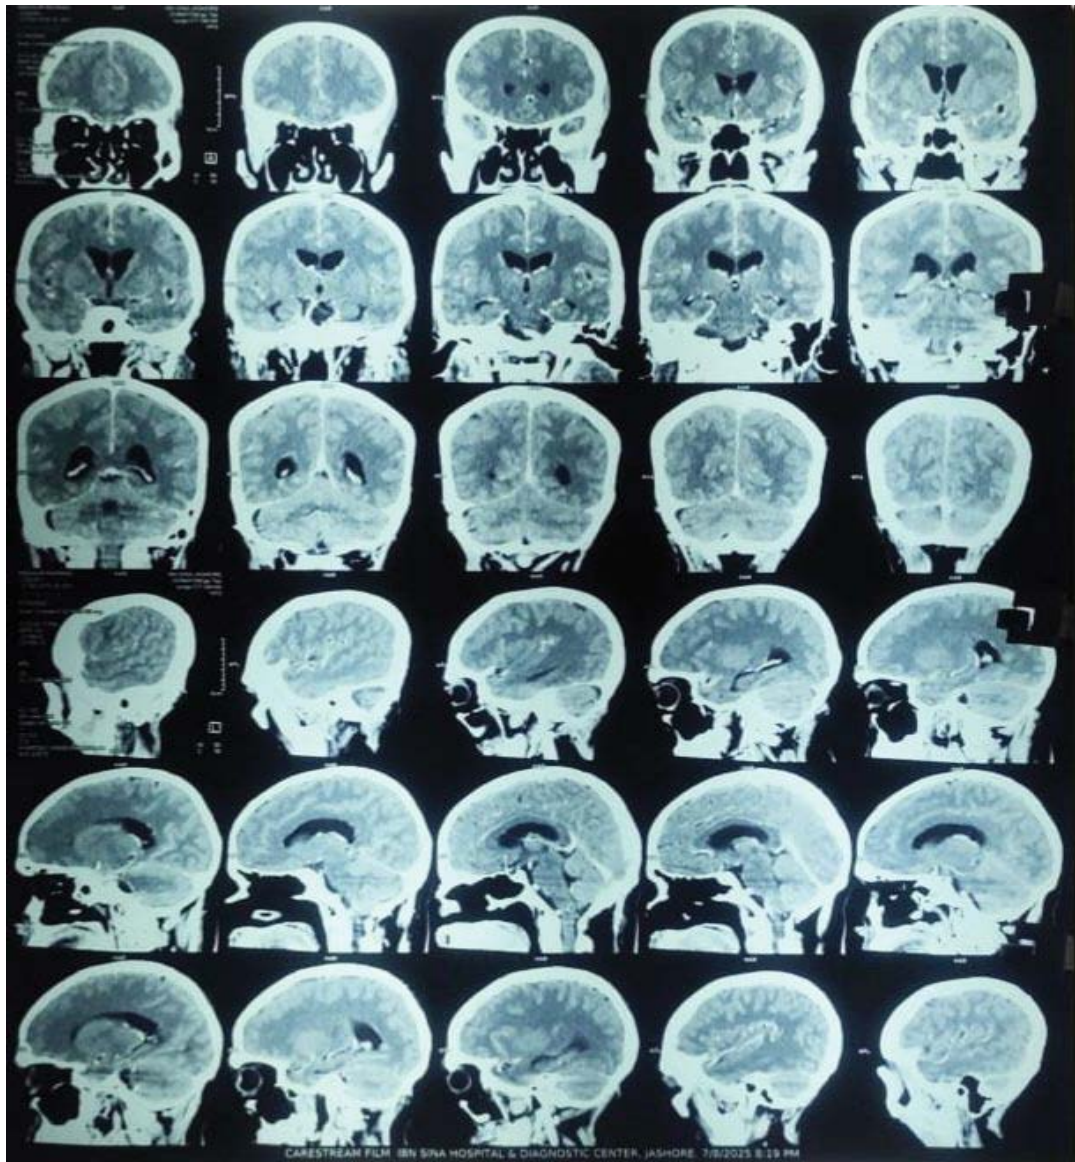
Image showing CT-Scan of brain which revealed status post-craniotomy in right half of the occipital and right temporal bones. No focal brain lesion was detected.
